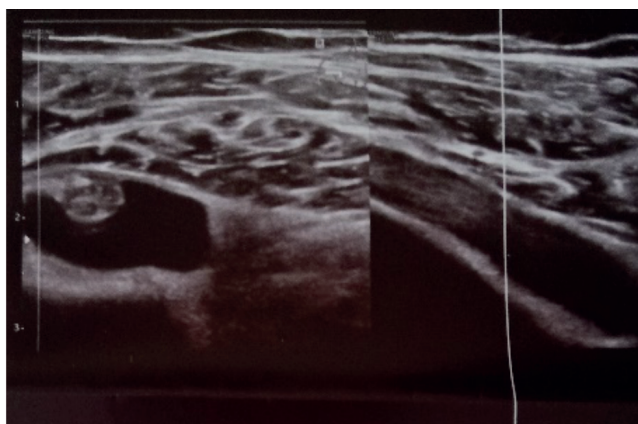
Image of the ultrasonographic exam of right shoulder: subacromial-subdeltoid bursitis. Modified from: Turrin *et al.* (2023).
